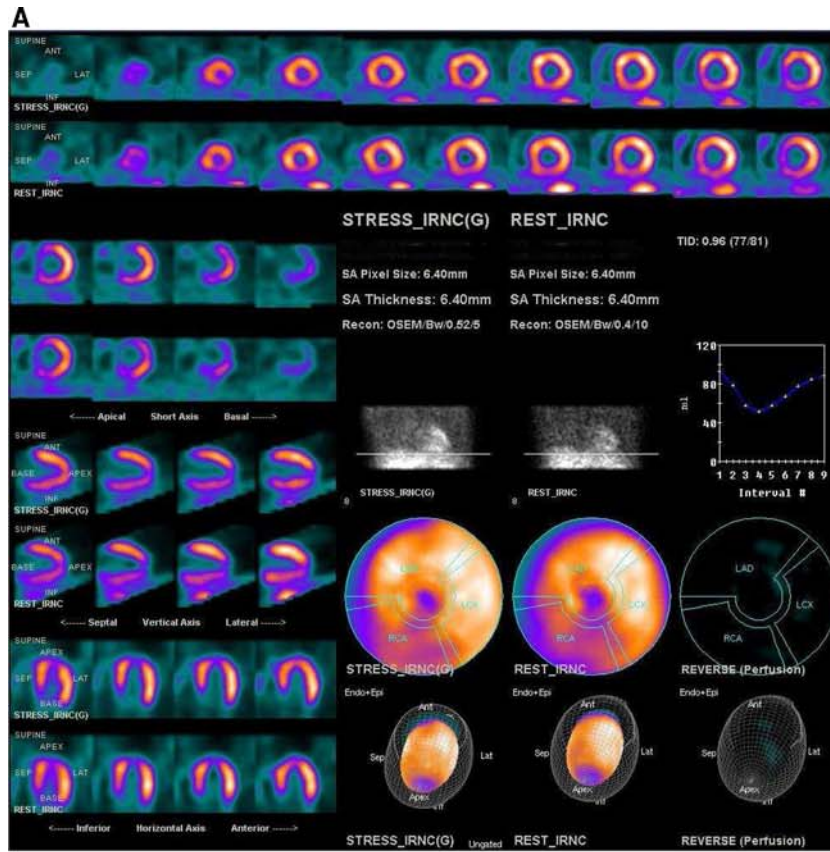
SPECT scans of a 56-year-old male hypertensive smoker with no prior history of coronary disease. Images obtained with Tc-99m sestamibi (dose: 8 mCi at rest and 32 mCi at stress) protocol and acquired with dual-head scintillation camera without attenuation correction. Images were reconstructed with full-time OSEM (15 minutes rest and 12 minutes stress) (A) and with separate wide beam reconstruction (WBR™) (9 minutes rest, 7 minutes stress) acquisitions (B) following the rest and stress OSEM acquisitions, respectively. The actual acquisition time for “half time” WBR is slightly longer than 1/2 due to the dead time associated with gantry rotation. However, the WBR acquisition time per camera stop is one-half that for OSEM. Both WBR and OSEM images show the same small apical defect which is likely physiological apical thinning. Images courtesy Dr. Gordon DePuey, Columbia University, New York City.
